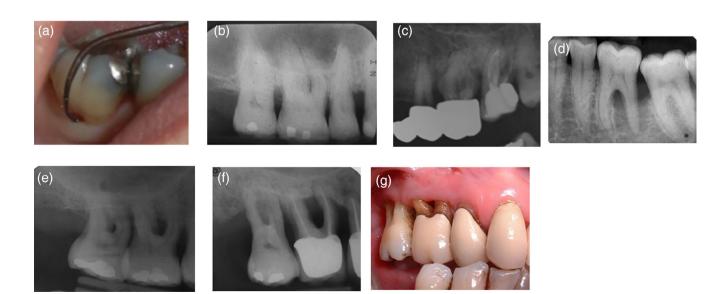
Clinical images and radiographs to assess competence in detecting and diagnosis furcation involvement (FI). (a) Nabers probe in furcation. (b) A long cone peri-apical (LCPA) showing FI in UR6. (c) A section of a dental panoramic tomograph with FI in UL6. (d) An LCPA showing FI in LL6. (e,f) LCPA and clinical photo of patients with FI III C on UR6 and UR7
